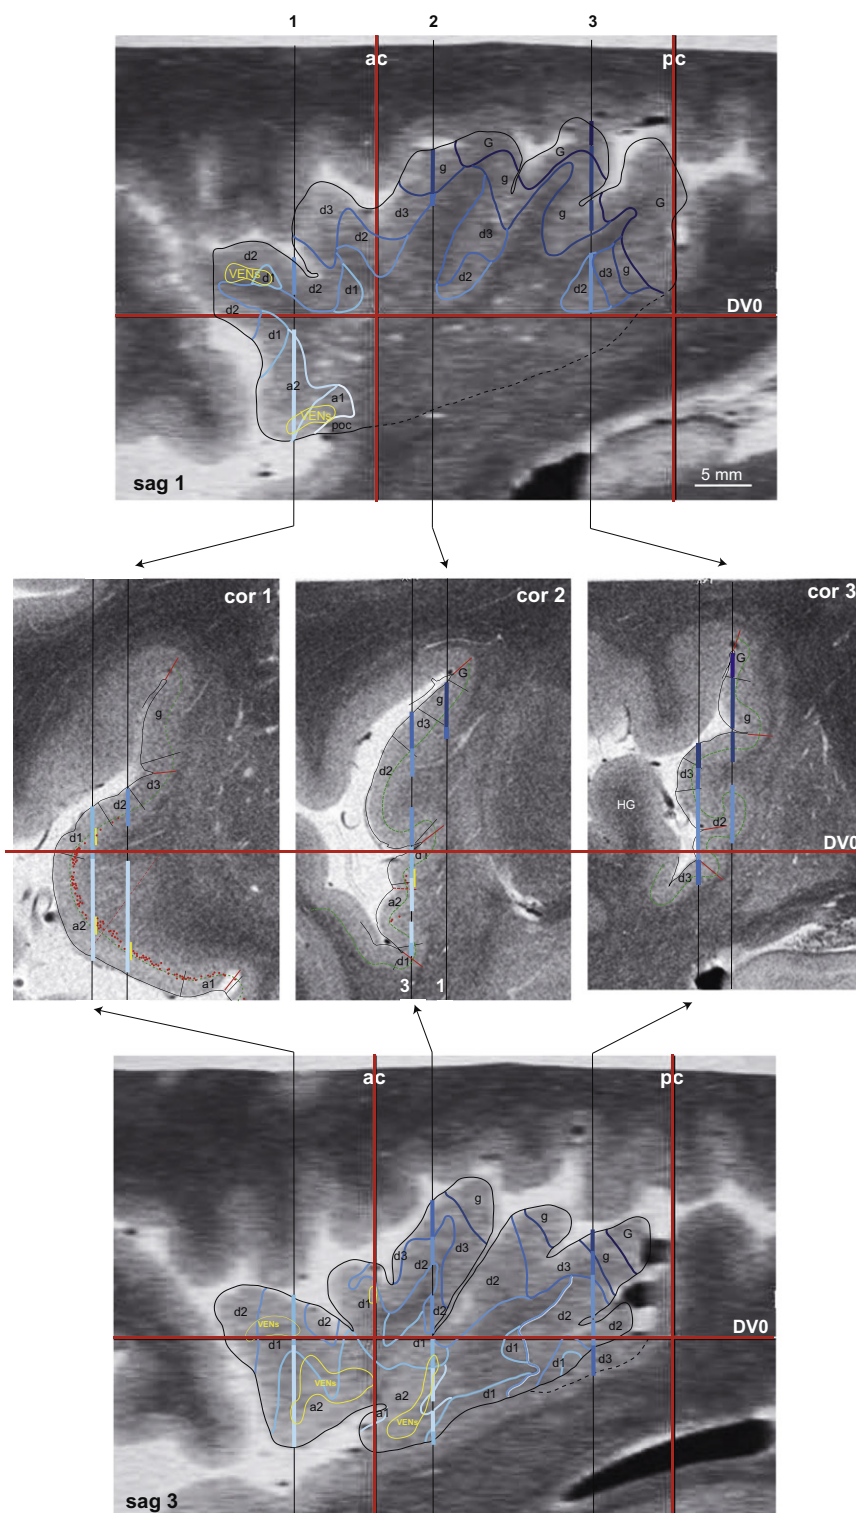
Procedure for sagittal MRI registration. Neurolucida plots of insular cytoarchitectonic borders (case Hb3-R) are projected onto corresponding coronal MRI (middle panels) where the position of planes corresponding to the sagittal medial (sag 1, upper panel) and lateral MRI (sag 3, lower panel) are represented by the two vertical lines. Colored segments (see color codes in Figs. 3 and 4) correspond to cytoarchitectonic subdivisions encountered in the grey matter. Positions of stereotactic planes are indicated by horizontal (DV0) and vertical (ac and pc) red lines. VENs distributions are represented by filled red circles in coronal section 1, and outlined by the yellow area in sagittal MRI reconstructions. See list of abbreviations.
